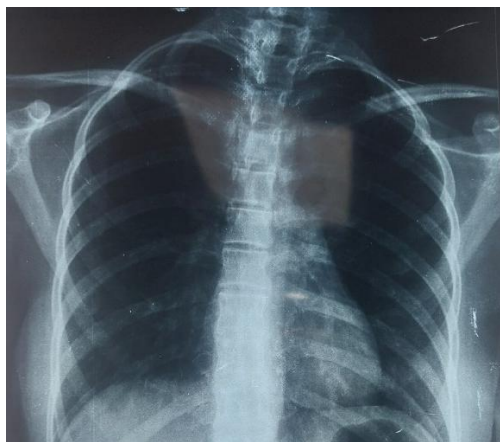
Normal chest radiograph.
